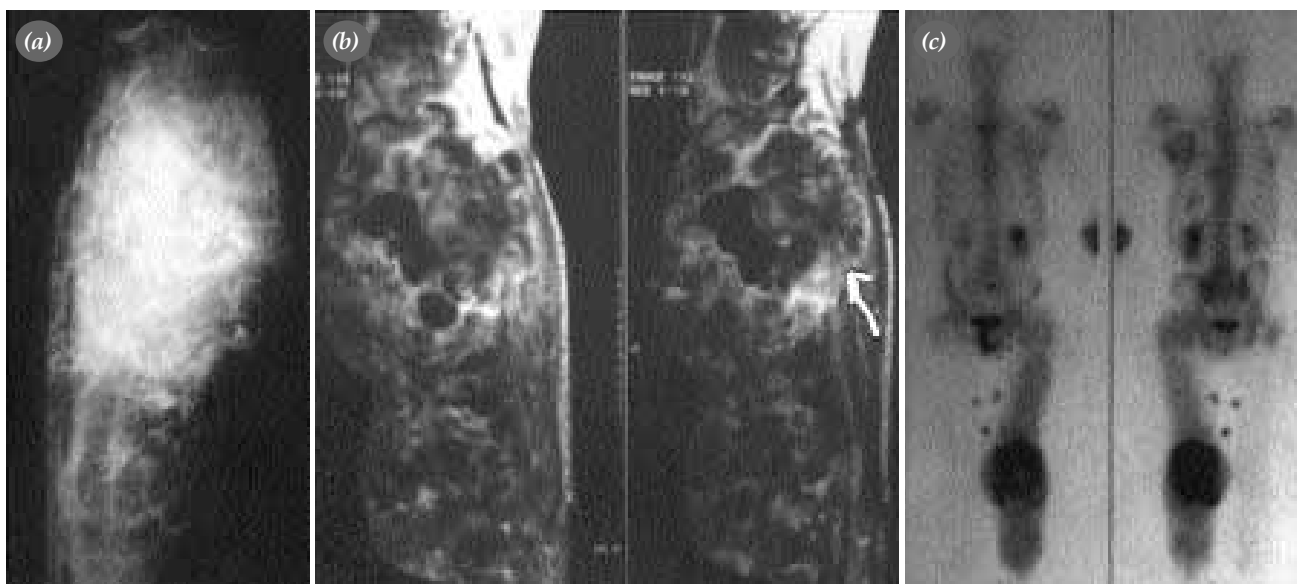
(a) Appearance of the widespread sclerotic and lytic foci with irregular borders involving the entire tibia and causing enlargement in the bone. (b) In the cross section of sagittal magnetic resonance imaging, extending of the lesion to soft tissue. (c) Distinctive involvement in the left tibia in whole body scintigraphy.
